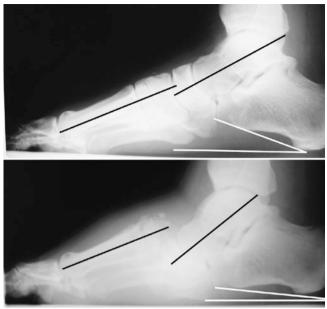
Lateral weight-bearing radiograph of the foot in the same patient before (top) and after (bottom) the development of a rockerbottom deformity. The calcaneal inclination angle (white line) has decreased and the talo-first metatarsal relationship (black line) is broken in the bottom image. (From Lee C. Rogers, with permission)
